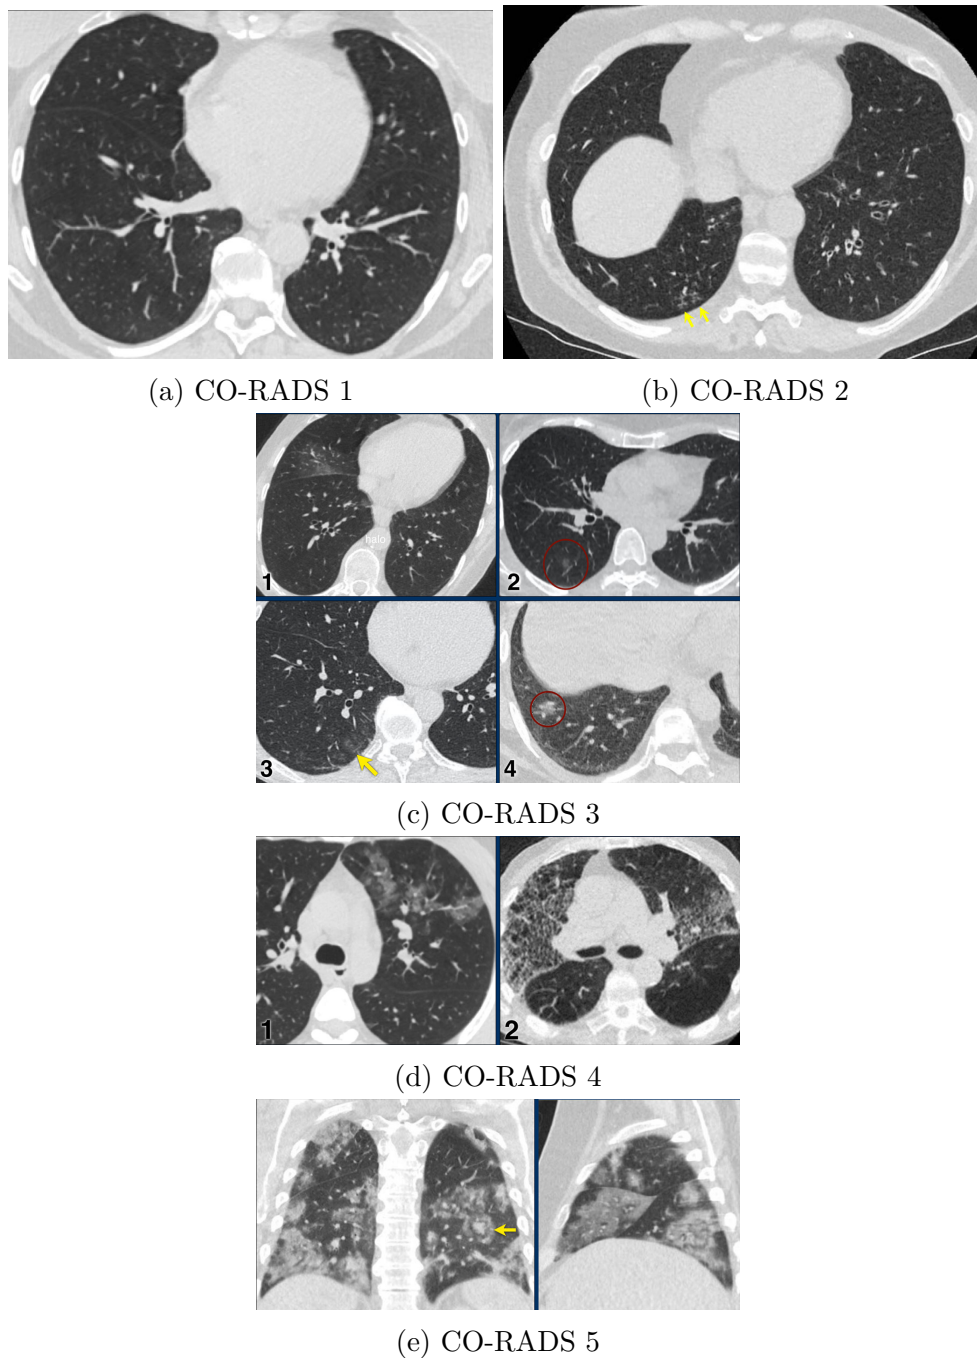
a: There are no significant findings, normal CT. b: CT shows bronchiectasis, bronchial wall thickening and tree-in-bud sign (yellow arrows), but there are no GGOs. Low suspicion of COVID-19 infection. c: Abnormalities indicating infection, but not certain whether COVID-19 is involved. Red circles and yellow arrow point to GGOs. d: High suspicion level, but findings are not extremely typical. Case 1 shows unilateral areas of GGO in left upper lobe. Case 2 shows bilateral GGO in a patient with emphysema. e: Typical COVID-19 findings, bilateral GGO. Images courtesy of Radiologyassistant, url: <https://radiologyassistant.nl/chest/covid-19/corads-classification>, accessed August 2020.
